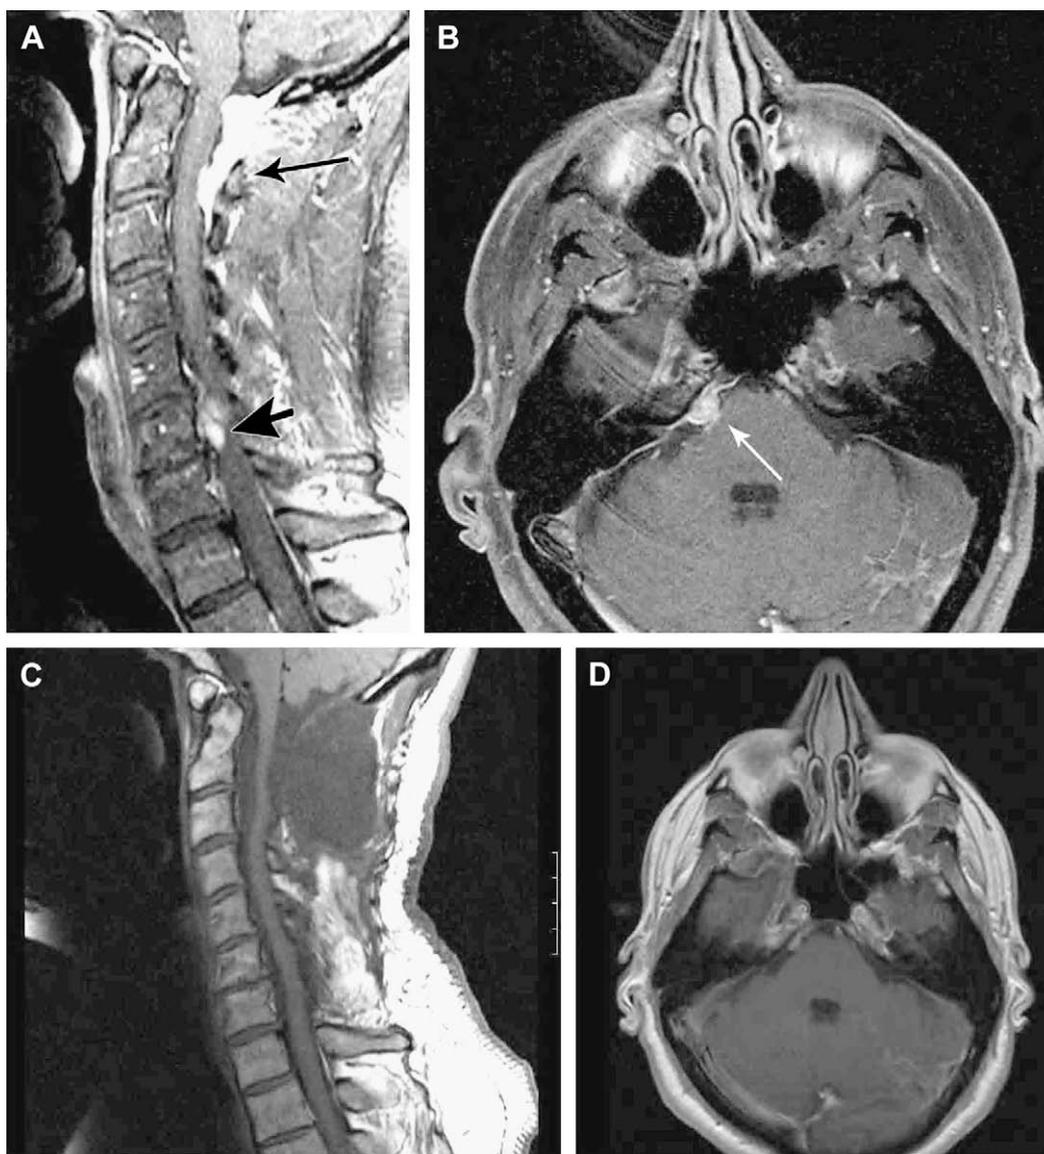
MRI findings for patient #1. Gadolinium-enhanced T1-weighted sagittal view (1A) demonstrated a large enhancing mass encroaching on the upper cervical spinal cord (arrow), with extension through the foramen magnum. There were also enhancing lesions in the lower cervical cord (arrowhead). Intraoperative findings revealed infiltration into the spinal cord and the nerve roots. Fig. 1B shows a transverse T1-weighted post-contrast image that revealed an enhancing lesion in the right cerebellopontine angle (arrow), with mild impingement on the pons and the right seventh and eighth cranial nerve root entry zone. Panels C and D demonstrate the MRI findings after treatment with infliximab.
